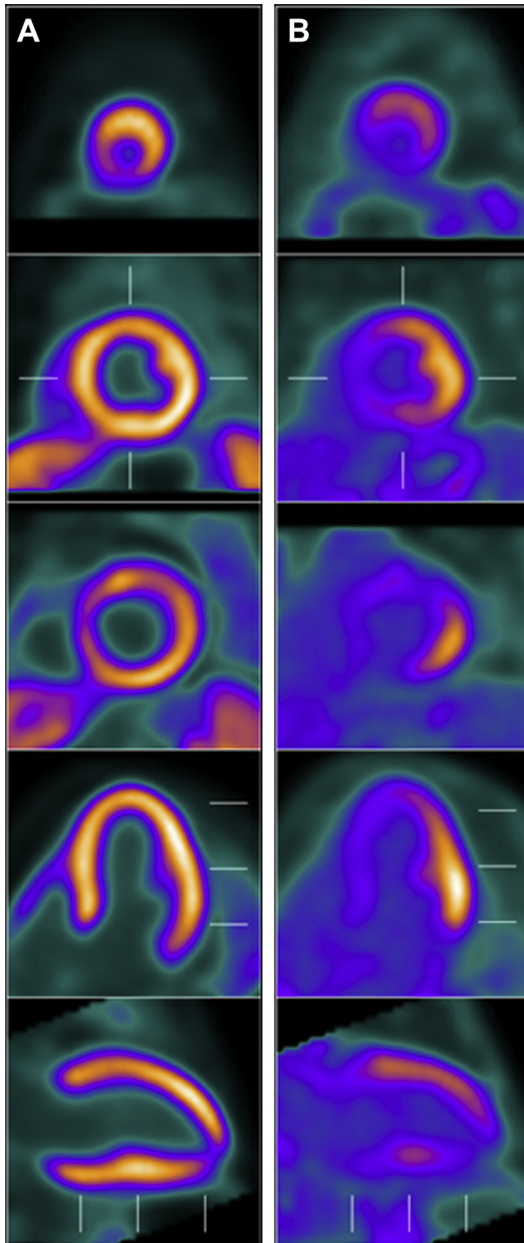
^{18}F -FDG and N-13 ammonia PET/CT for CS. No perfusion defects are present on N-13 ammonia imaging (A). ^{18}F -FDG images demonstrated diffuse uptake throughout the entire myocardium with areas of focal and diffuse uptake. These findings are nonspecific and are likely secondary to ineffective suppression of physiologic myocardial glucose uptake (B). *Panel A* is the perfusion panel as listed. From top to bottom is apex, mid, and base then horizontal and vertical long axis. *Panel B* is FDG panel as listed and from top to bottom is apex, mid, and base then horizontal and vertical long axis.
